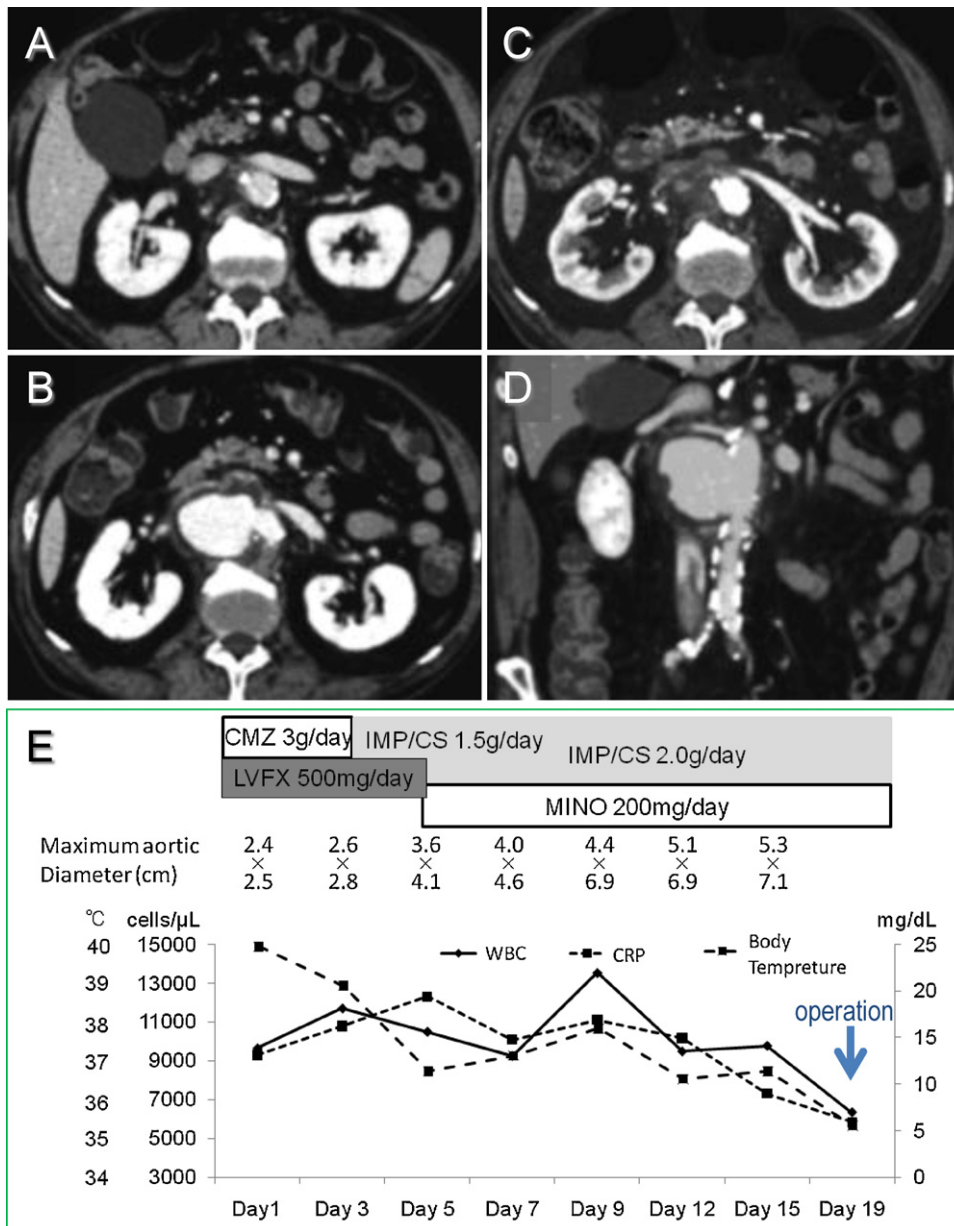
A 78-year-old man who had been diagnosed to have hypertension and hypertrophic cardiomyopathy was referred to our hospital because of high fever (40°C) and abdominal pain. On day 5 of hospitalization, *Bacteroides thetaiotaomicron* was identified in blood culture. (A–C) Transverse sections of computed tomographic (CT) scanning images. (D) Coronal section of CT image. (A) On the day of admission. (B) 5th hospital day. (C and D) 12th hospital day. The diameter of the aortic aneurysm showed rapid dilatation. (E) Clinical course of the patient. CMZ, cefmetazole; LVFX, levofloxacin; IPM/CS, imipenem/cilastatin; MINO, minocycline; CRP, C-reactive protein; WBC, white blood cell.
